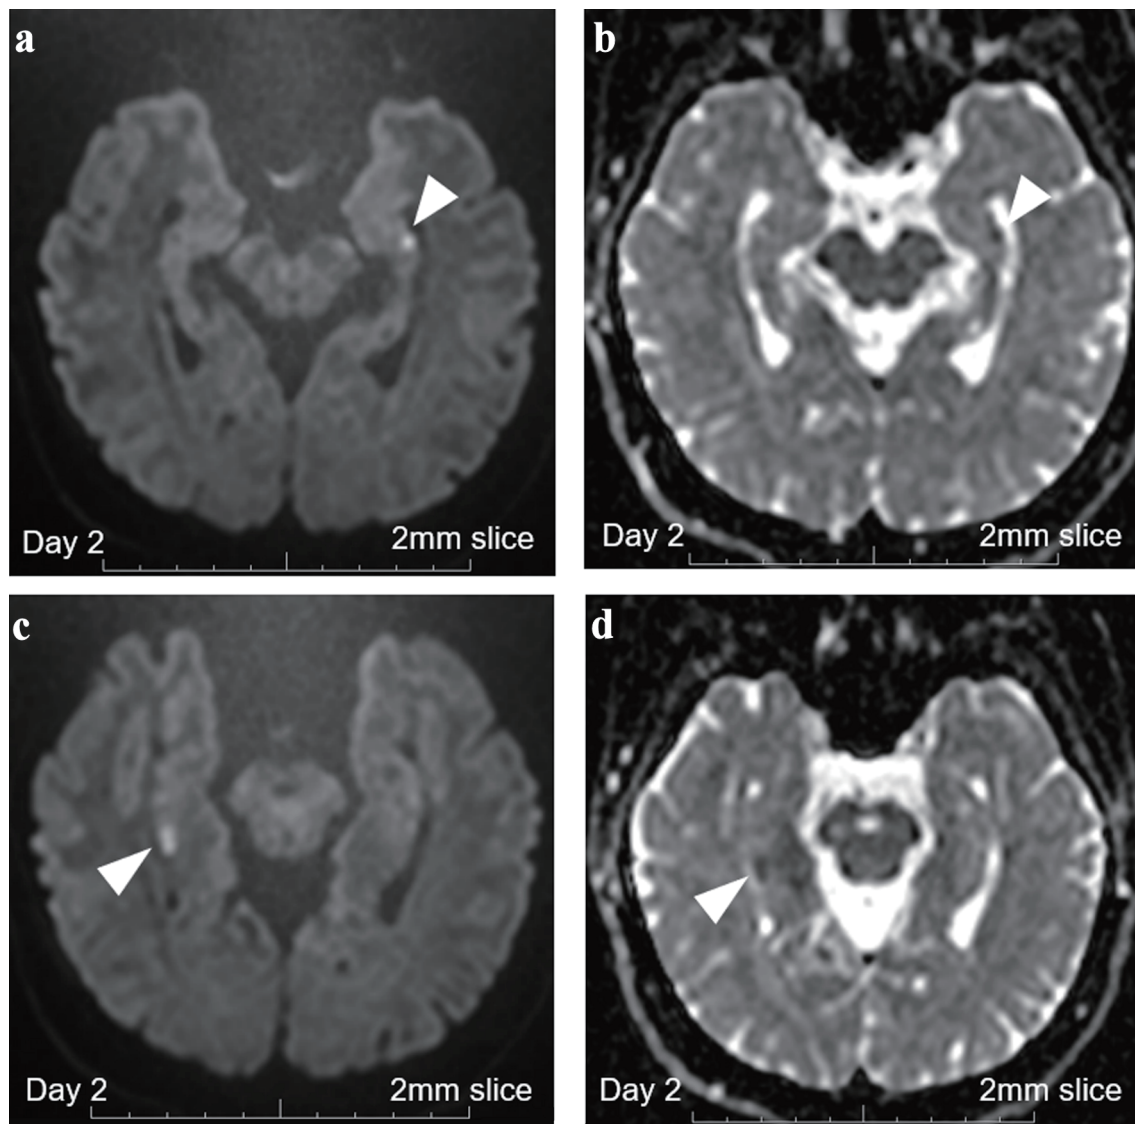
Brain MRI with 2-mm thin-slice on day 2. (a) DWI with 2-mm thin-slice brain MRI on day 2 revealed persistent punctate hyperintense DWI signals in the left hippocampus (white arrowhead). (b) ADC with 2-mm thin-slice brain MRI on day 2 revealed persistent punctate signal loss in the left hippocampus (white arrowhead). (c) DWI with 2-mm thin-slice brain MRI on day 2 revealed persistent high signals in the right hippocampus (white arrowhead). (d) ADC with 2-mm thin-slice brain MRI on day 2 revealed persistent signal loss in the right hippocampus (white arrowhead). MRI: magnetic resonance imaging; ADC: apparent diffusion coefficient; DWI: diffusion-weighted imaging.
